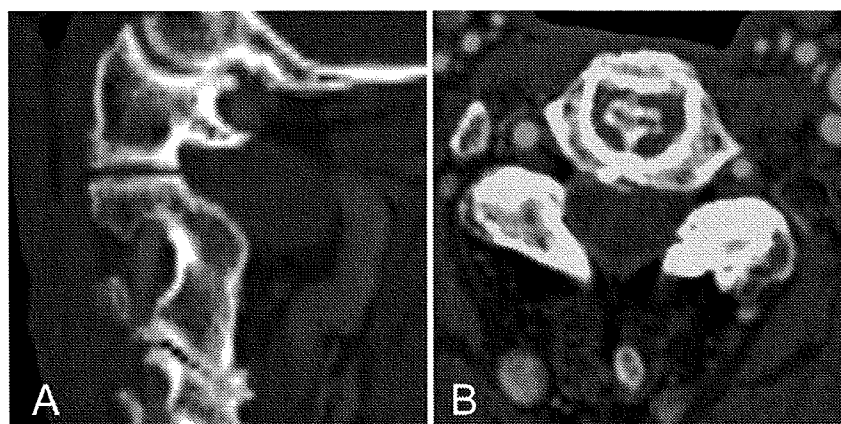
Sagittal (A) and axial (B) CT reconstructions (both from patient 8) demonstrated severe spondylosis in bilateral C2 to C3 zygapophysial joints.
